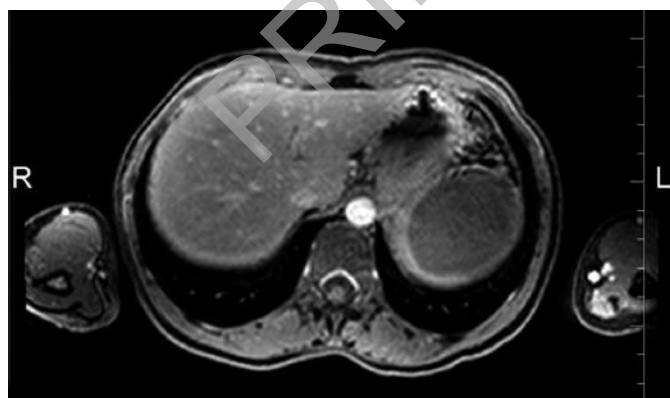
Preoperative MRI scan showed the splenic cyst.
